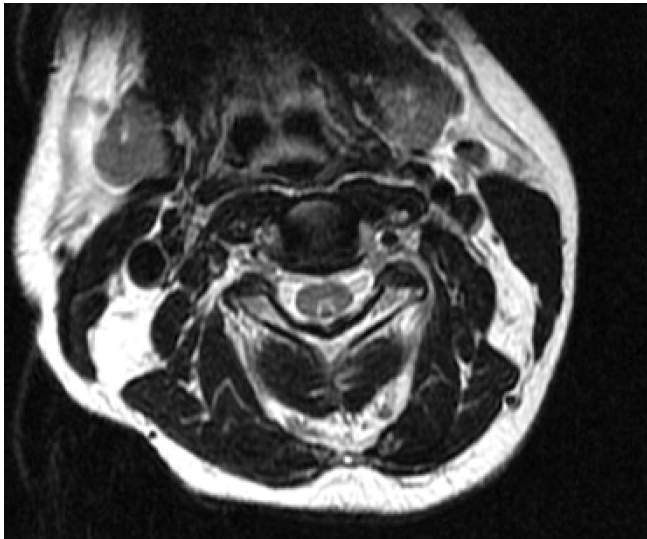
Inverted V-Sign on T2 Sequence Axial Cut of MRI Cervical Spine with Contrast.
